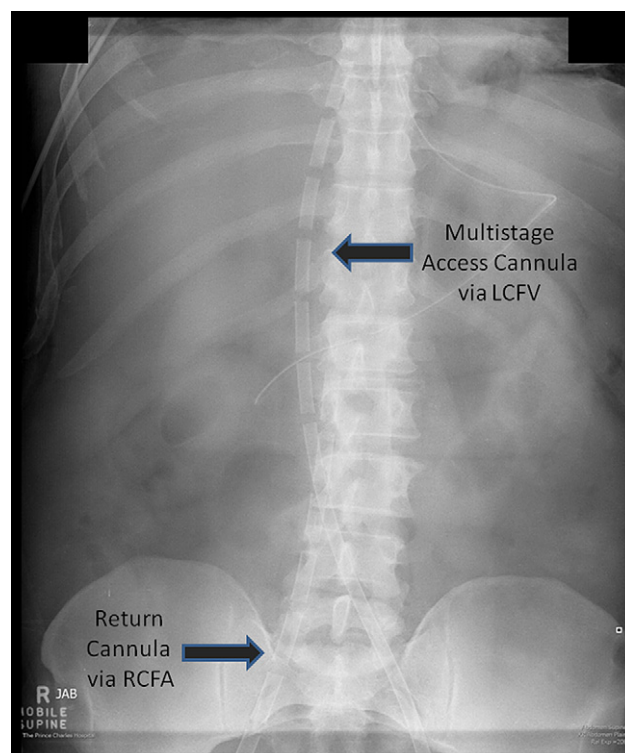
Plain abdominal x-ray showing a venous access cannula inserted via the left common femoral vein (LCFV) into the right heart and an arterial return cannula inserted via the right common femoral artery (RCFA) into the abdominal aorta.
